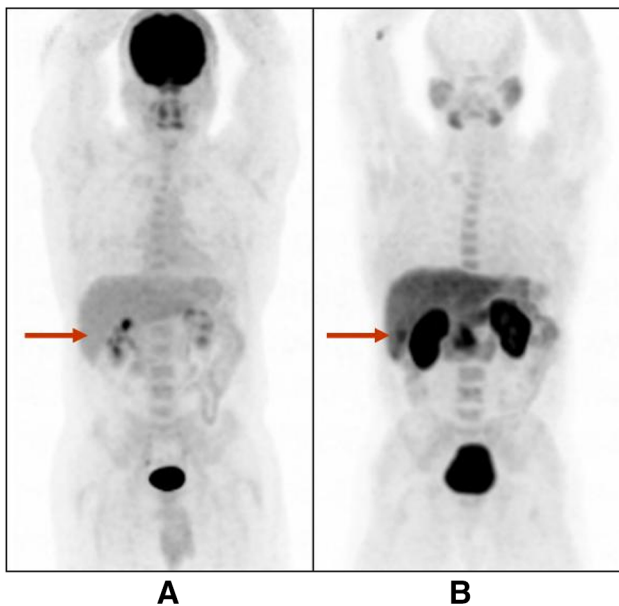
Infrequently, liver adenoma can also be FDG-negative (a) and FCH-positive (b), as in this patient with a solitary adenoma (color figure online)
